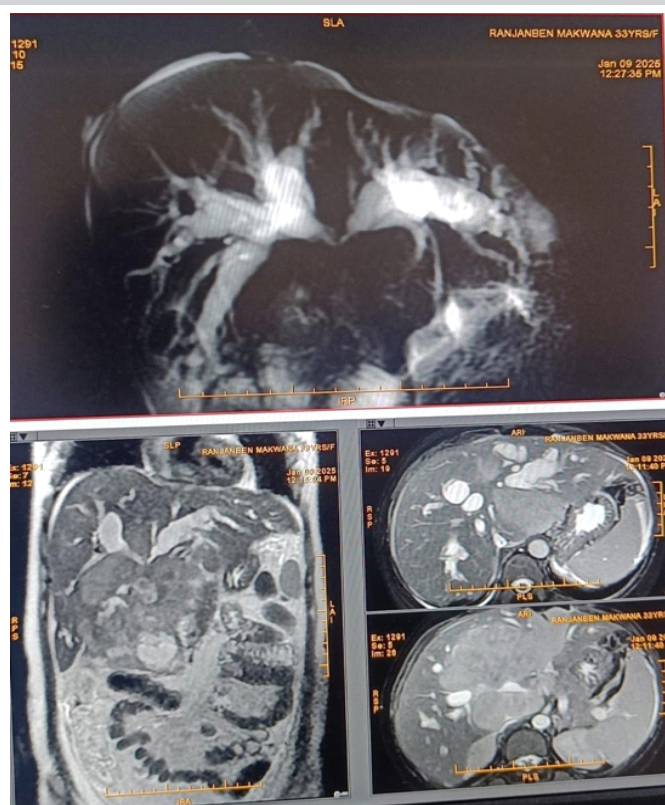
Triple phase magnetic resonance imaging abdomen. Triple-phase abdominal magnetic resonance imaging. Coronal and axial contrast-enhanced images demonstrate a large, multi-lobar hypervascular intrahepatic tumor in the left liver lobe with classical arterial enhancement and venous phase washout (LI-RADS 5), underlying background cirrhosis, dilated intrahepatic bile ducts, and an invasive left portal vein tumor thrombus.
